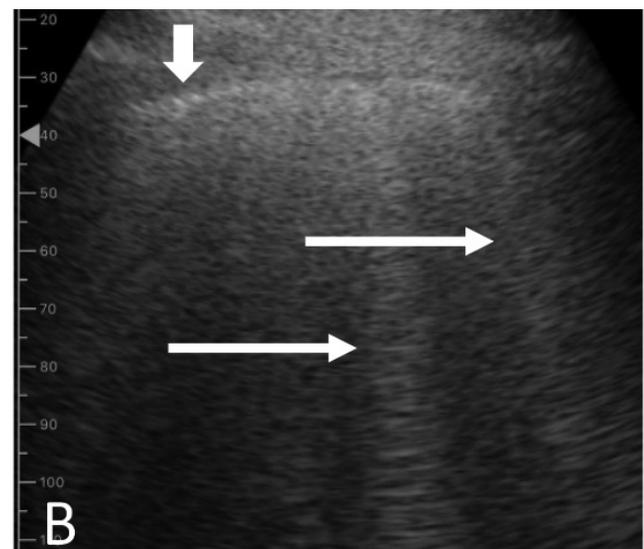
Lung ultrasound scan showing a vertical artifact (B-line, thin arrow) in the context of otherwise normally aerated lung with normal pleural line (white thick arrow)
